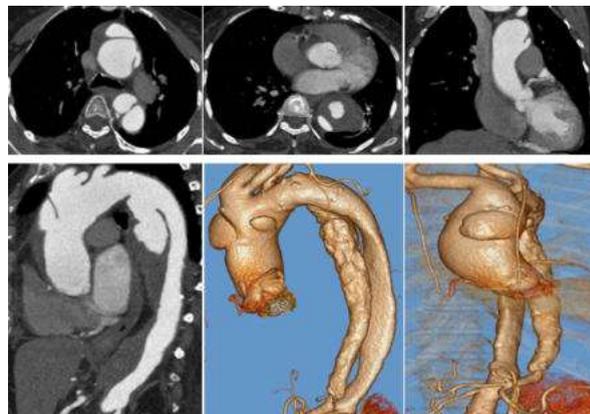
(A-F). CT Aortic angiogram Axial (A,B), Coronal (C,D) and 3 D volume rendered images (E,F) showing 2 small focal ascending aortic aneurysmal fissuring, a larger descending thoracic and abdominal aortic fissured aneurysm.
